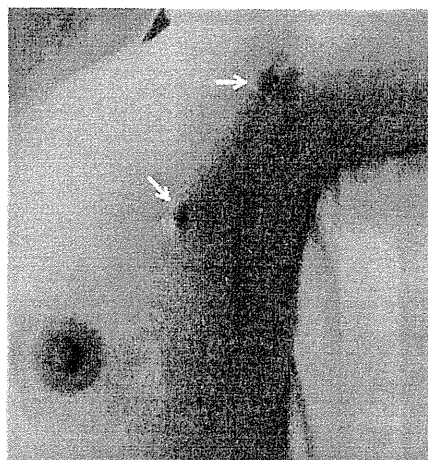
Pre-MRI lymphography marking. Two points along the lateral edge of the pectoralis major are marked with pills, the first point is the insertion at the humerus, the second is the junction of the lateral edge of the pectoralis and mammary line (arrows)
